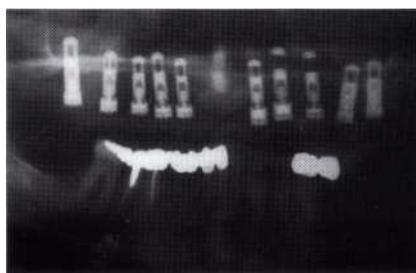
A panoramic radiograph showing implant fixtures placed after bilateral maxillary sinus lifts with cancellous bone graft from the iliac crest.
